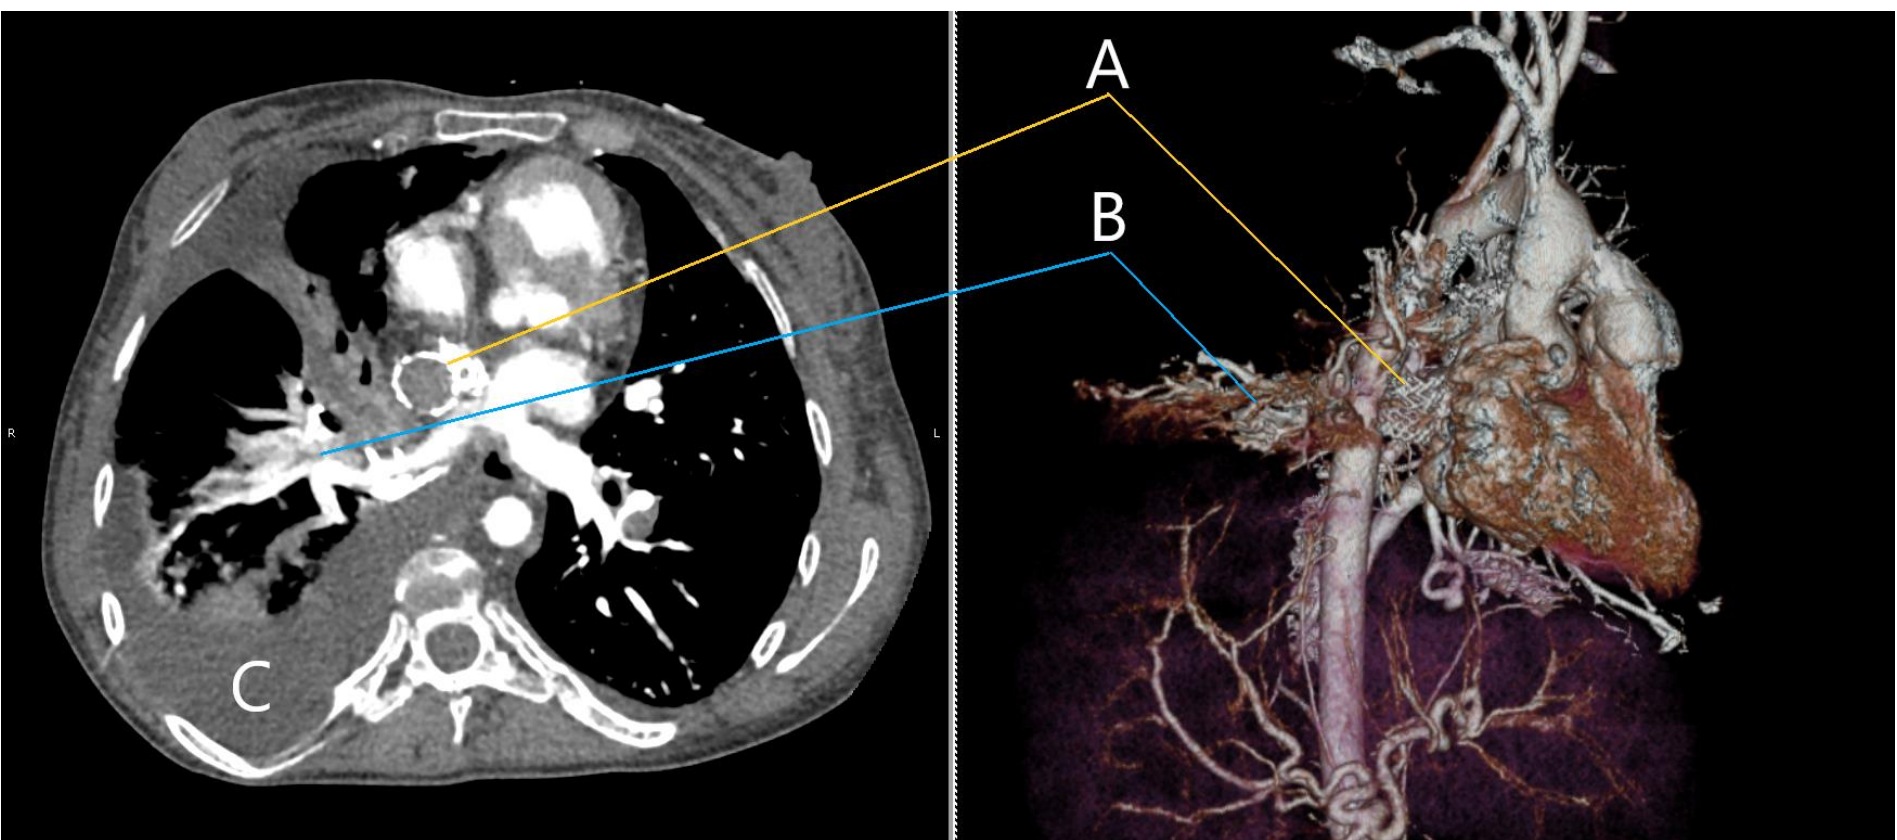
CT Chest revealed the Fontan conduit (A), dilated sub-pleural pulmonary vessels concerning for AVMs (B), right pleural effusion (C), portosystemic venous shunt, esophageal and inferior epigastric varices.
